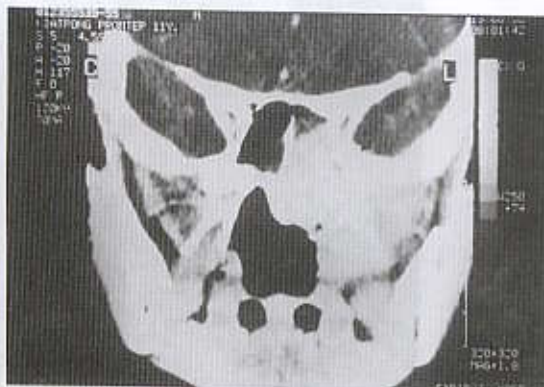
Coronal CT imaging of the nasopharynx at a clinical stage T2 reveals tumor extension into the cranial vault thus the CT stage is stage T4.
